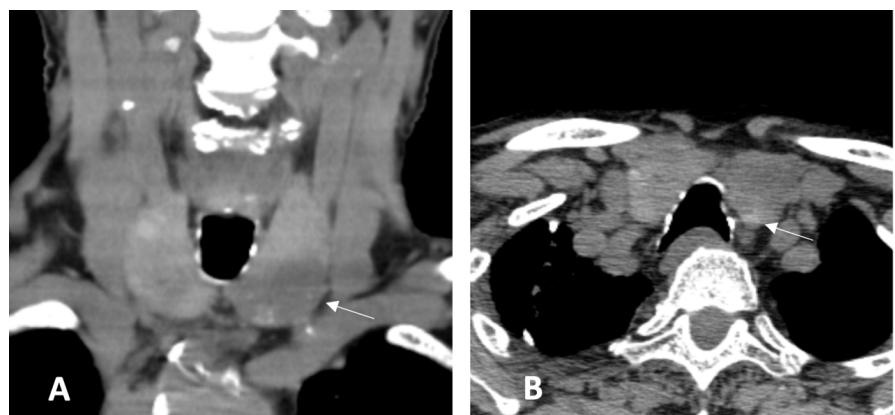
Follow-up computed tomography in coronal (A) and axial (B) planes at 12 months demonstrates a significant reduction in the size of the left thyroid lobe (white arrow).
